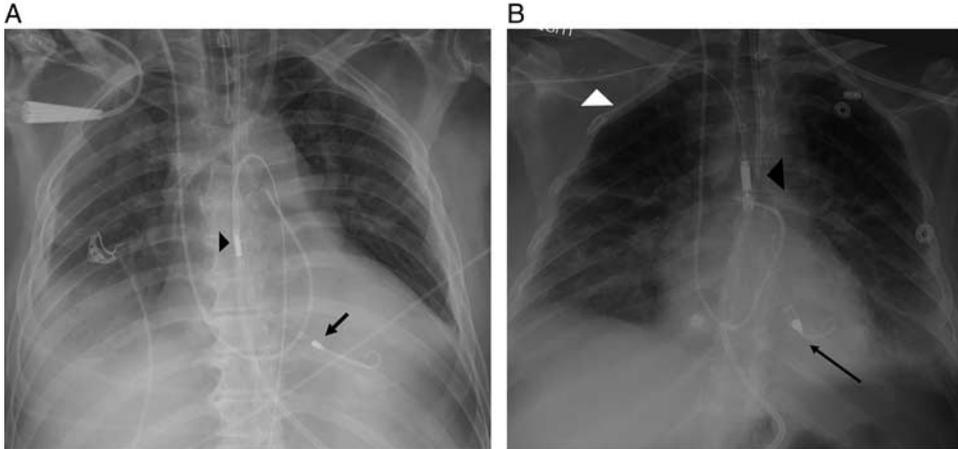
Temporary LVAD—Impella catheter: frontal radiographs depicting femoral (A) and right subclavian (white arrowhead) approach (B) Impella catheter with radiopaque marker above (black arrowhead) and below the level of the aortic valve (black arrow). The LV marker is the pump inflow, whereas the aortic marker represents the outflow.
